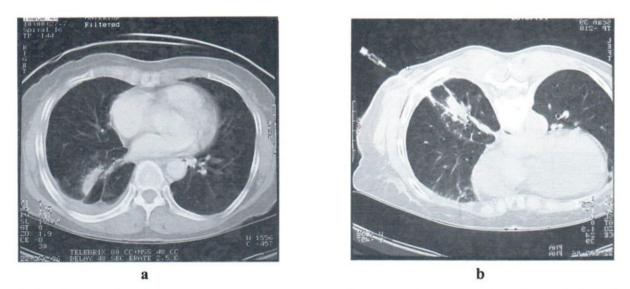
a,b CT scan after 3 month post ablation shows decreased in size of thin wall cavity with pleural thickening. There was a progressive tissue thickening at the anterior wall of the cavity (a). FNAB was performed (b) and tissue analysis proved to be a recurrent tumor.
